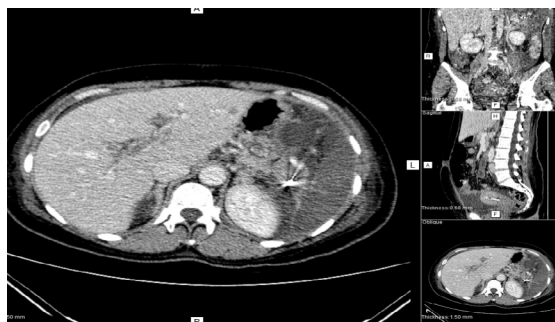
CTA 5 days after the endovascular treatment showing thrombus in portal vein.
